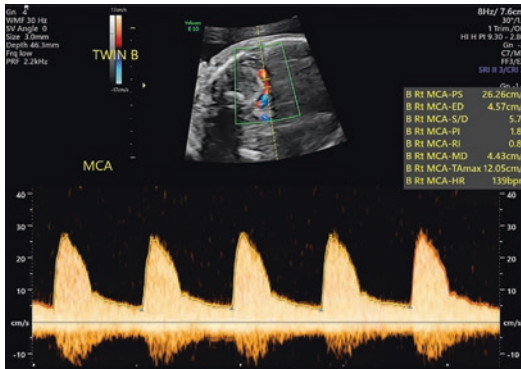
Typical example of a duplex Doppler display. *Top*: Two-dimensional gray-scale and color Doppler image of the fetal middle cerebral artery. The spectral Doppler beam path is indicated by the *dotted cursor line*. The Doppler sample volume is indicated by *two horizontal lines*. *Bottom*: Spectral Doppler frequency shift waveforms from the sampled middle cerebral artery location
